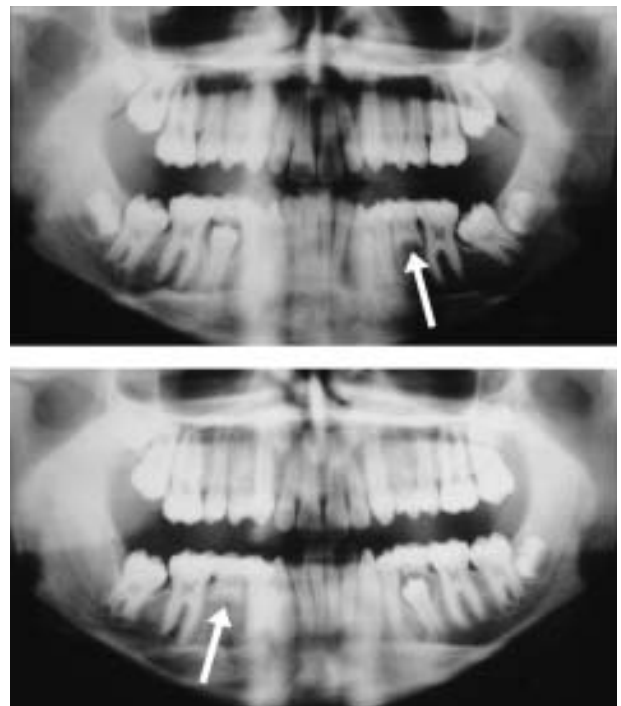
Orthopantomographs of a pair of 14-year-old MZ twin boys displaying mirror-imaging for agenesis of a lower second premolar (arrowed).
